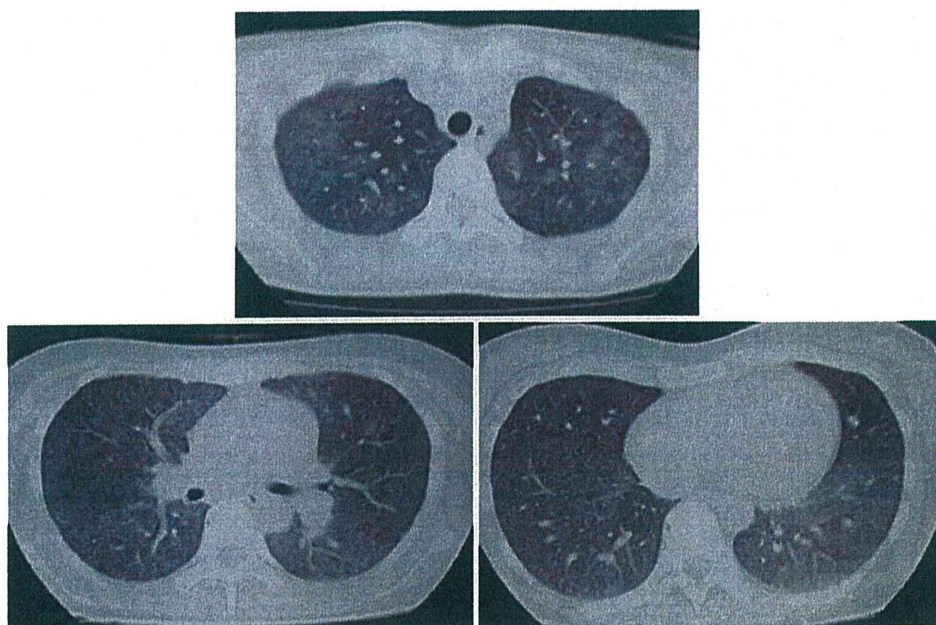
Chest computed tomography (CT) at the onset of *Pneumocystis jiroveci* pneumonia in Case 2. A ground-glass pattern is seen bilaterally in the lungs
